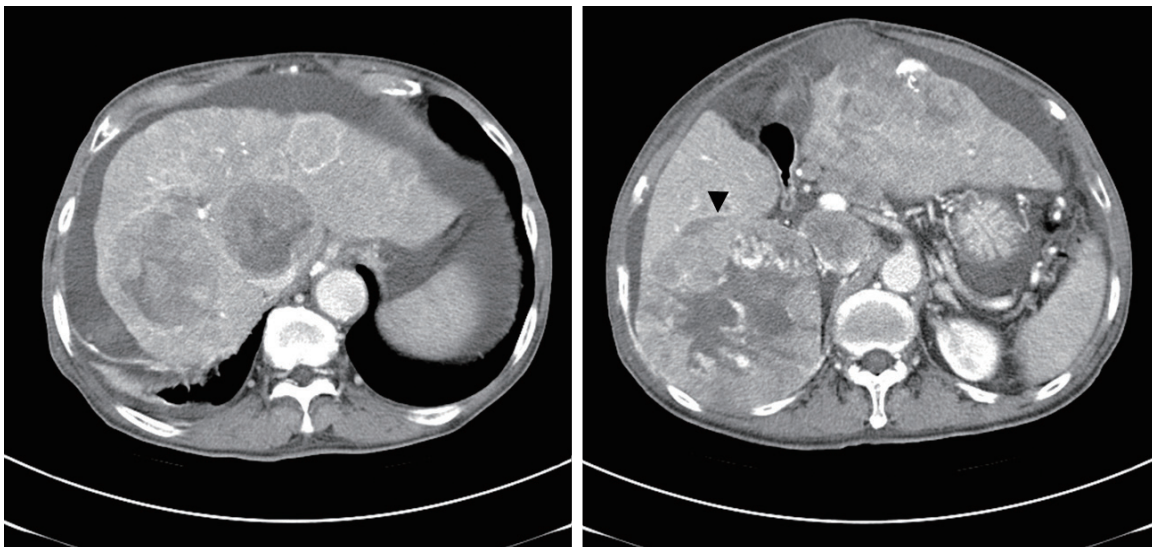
Abdominal computed tomography with enhancement performed about 1 month prior to this admission revealed multiple viable HCCs in both lobes of the liver. The largest of these tumors had a diameter of 10.7 cm (arrow head).
